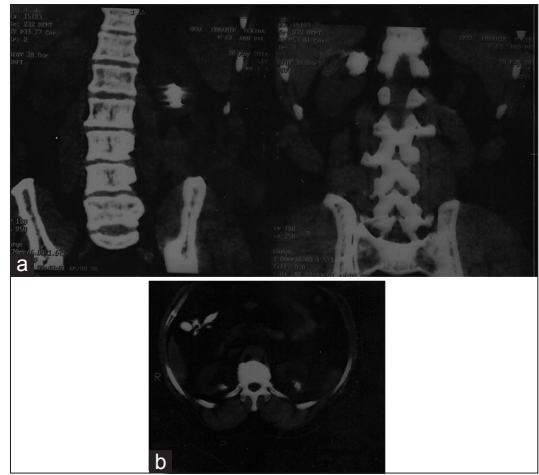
(a and b) Representative follow-up transverse noncontrast CT scan obtained 3 (a) and 6 (b) months after the procedure shows shrunken cysts filled with the mixture of n-butyl cyanoacrylate and iodized oil on CT images of bilateral simple renal cysts in a 53-year-old man
